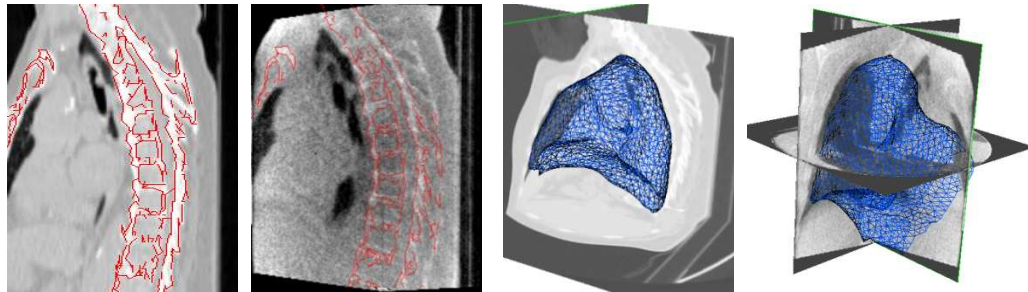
The major process of generating initial lung shape model in the MVCBCT coordinate: (a) bony structures (red) segmented from 4D planning CT; (b) The alignment of the bony structures onto the fully reconstructed MVCBCT; (c) Triangulated lung mesh segmented from the FE phase of 4D planning CT; (d) The lung mesh transformed to the MVCBCT coordinate.
